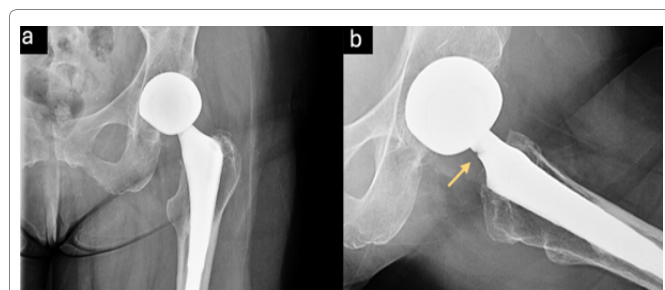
Case 4: Pre-revision anteroposterior (a) and lateral (b) radiographs with posterior femoral notching.
